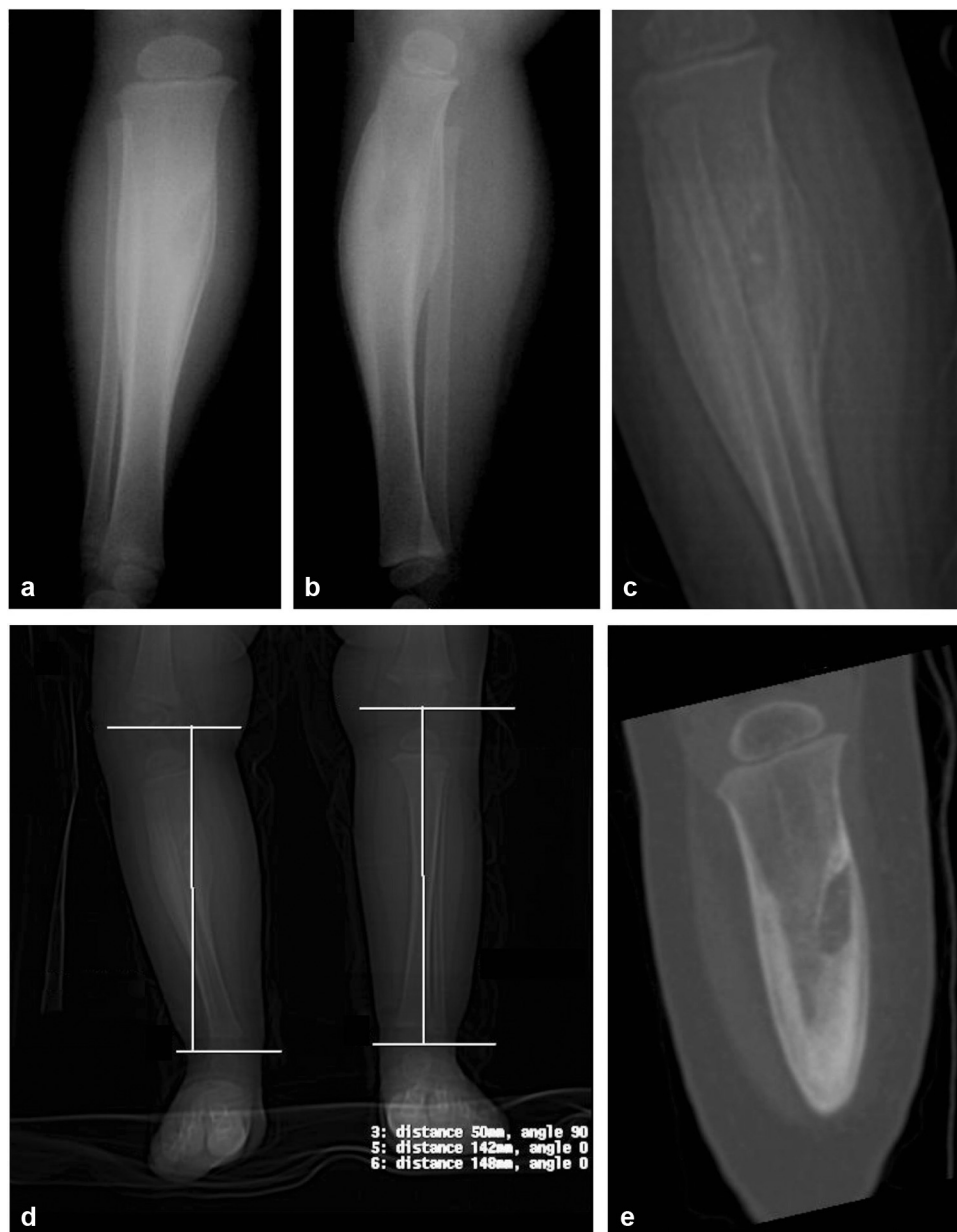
Osteolytic lesion with sclerosis and calcifications in the right tibia; a, roentgenogram AP; b, profile, c, magnification; d, scanometry; e, coronal oblique reformation.
